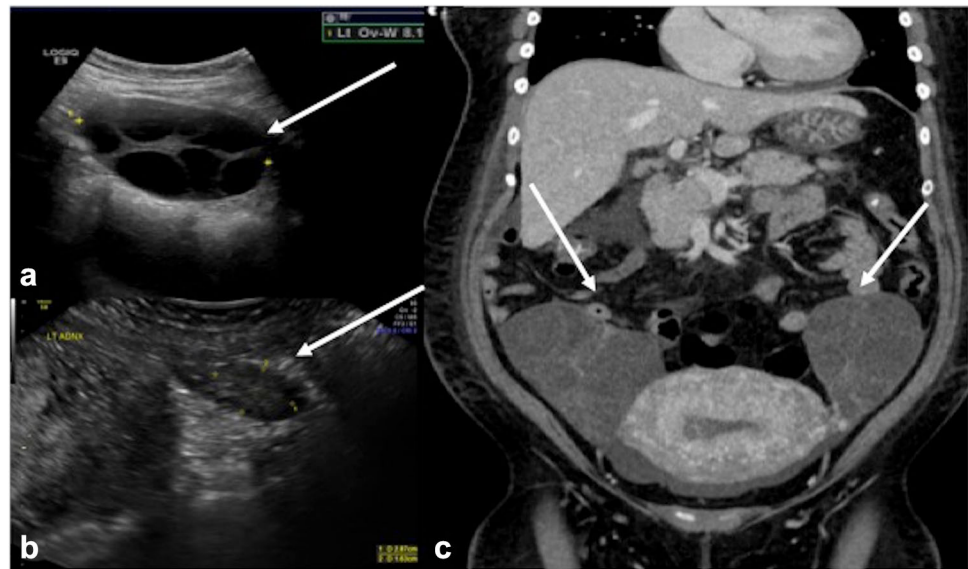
A 28-year-old woman with positive pregnancy test and vaginal bleeding. a Transvaginal ultrasound of a patient with elevated b-HCG shows markedly thickened endometrium with multiple cystic
